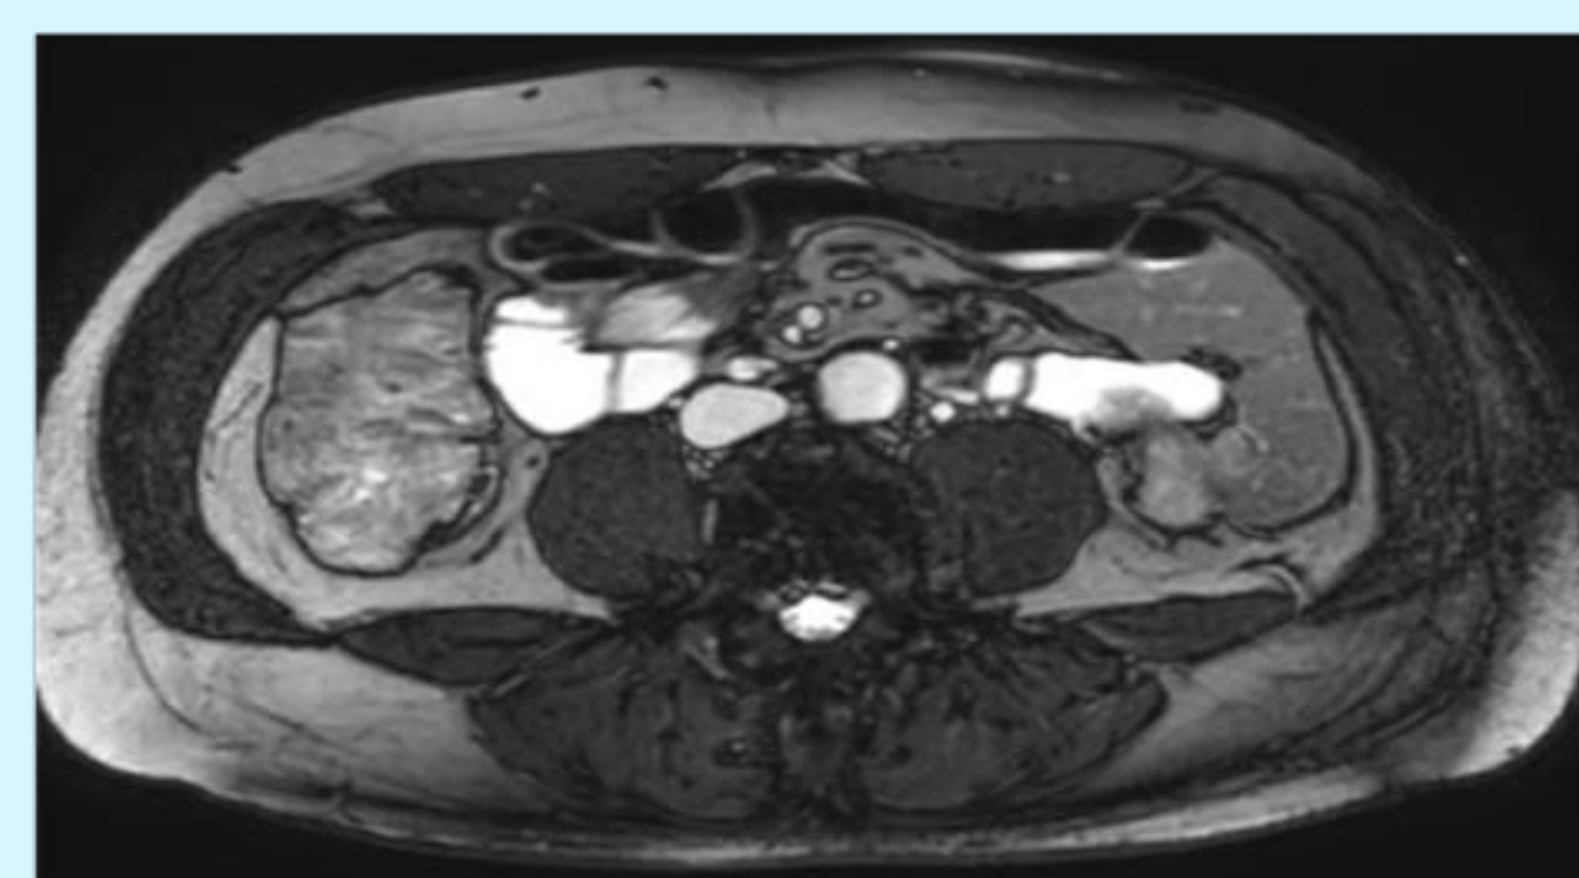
T2-weighted MRI Abdomen of ascending colon wall thickening resembling a mass
